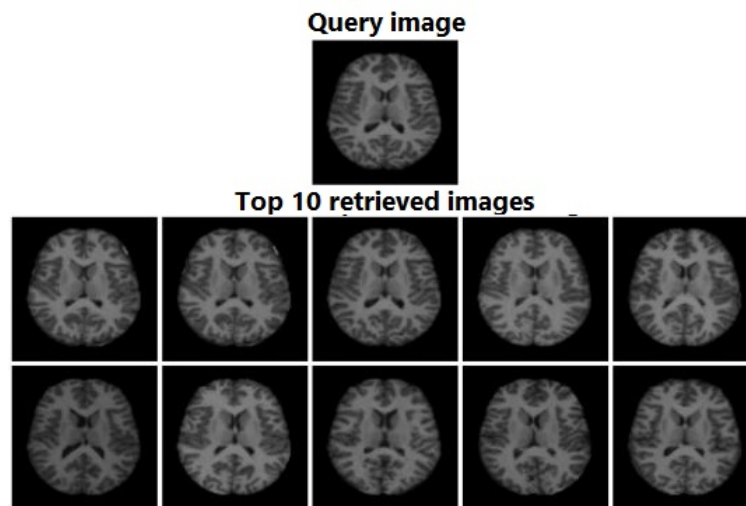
Retrieved images for an OASIS-MRI dataset query using RbQE with AlexNet.
